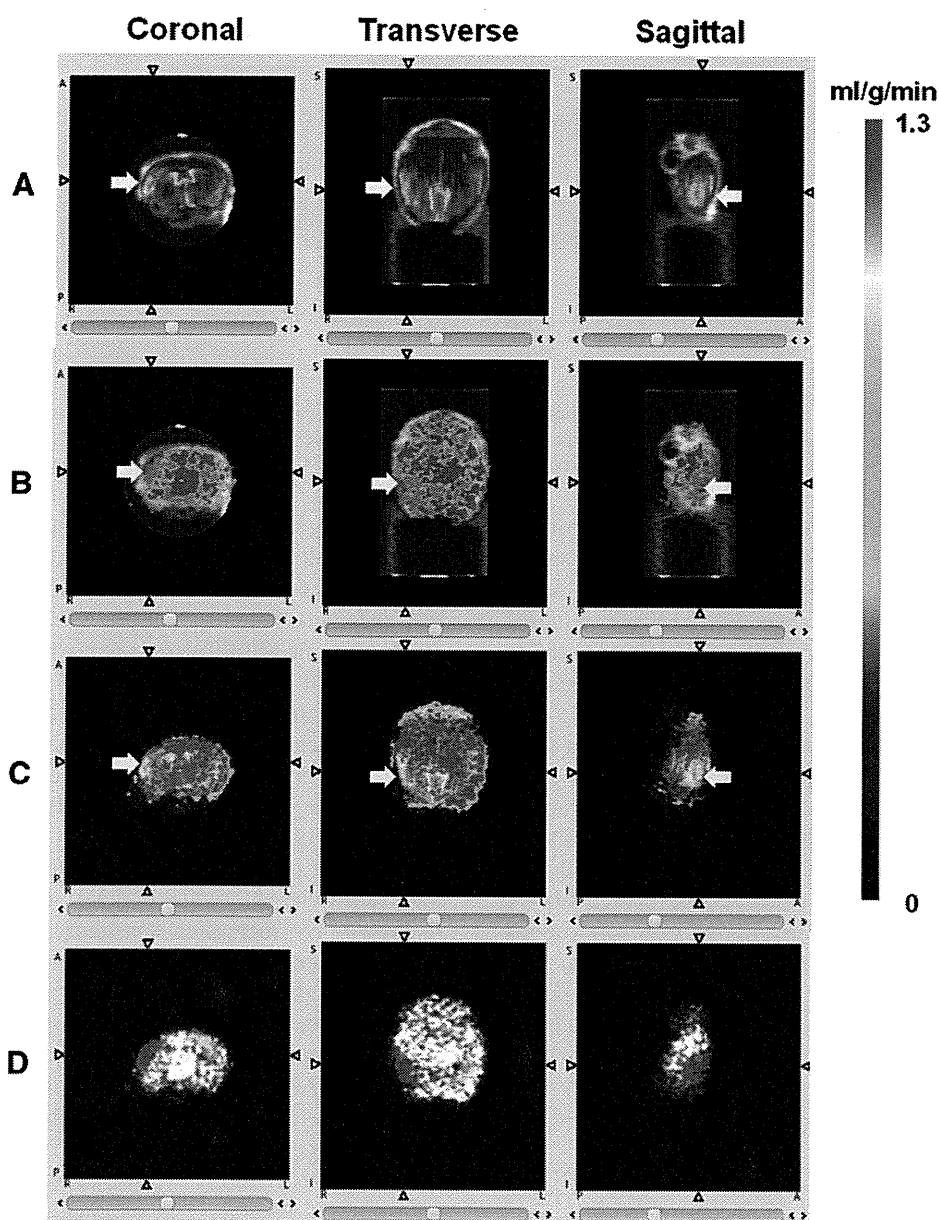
Representative aligned images and ROIs drawn on CBF images. A gray scale, a hot-metal color scale and a rainbow color scale are used to display X-ray CT, MR and CBF images, respectively. The MR image was digitally processed to remove skin and muscle. (A) MR image superimposed on the X-ray CT image. (B) CBF image superimposed on the X-ray CT image. (C) Superimposition of MR and CBF images. Arrows indicate infarcted areas. The attached color scale bar is for CBF images in (B) and (C). (D) CBF image and ROIs (red: infarcted area; green: region opposite the infarcted area). These ROIs were determined from the MR image.
